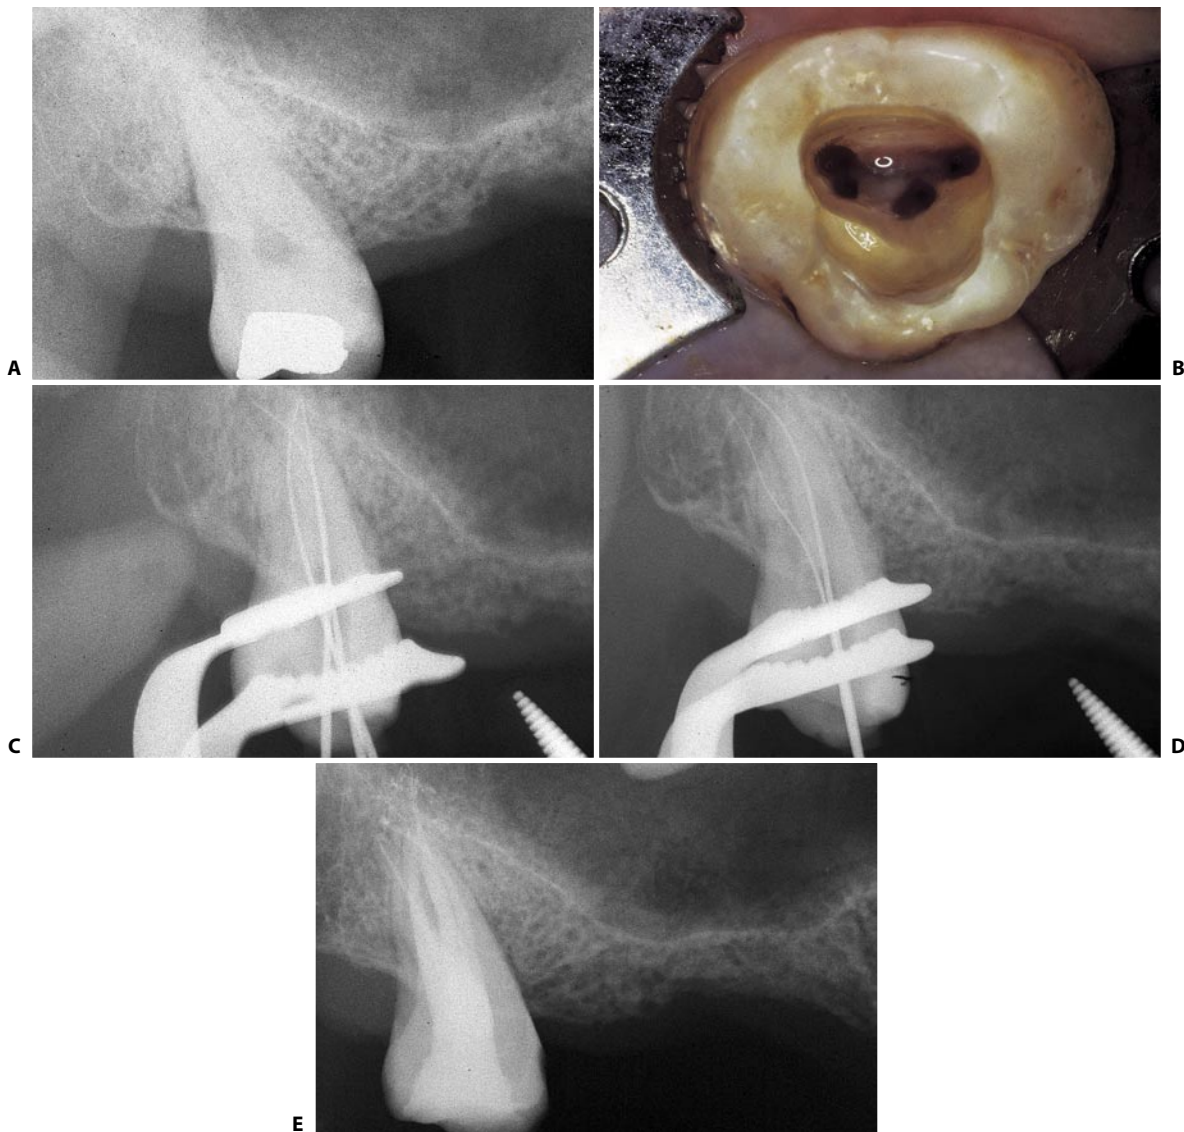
A. Preoperative radiograph of the upper right third molar. B. The access cavity of the same tooth shows the presence of four canals. C. The two palatal canals have independent foramina. D. Two instruments have been introduced in the buccal canals. E. Postoperative radiograph.
